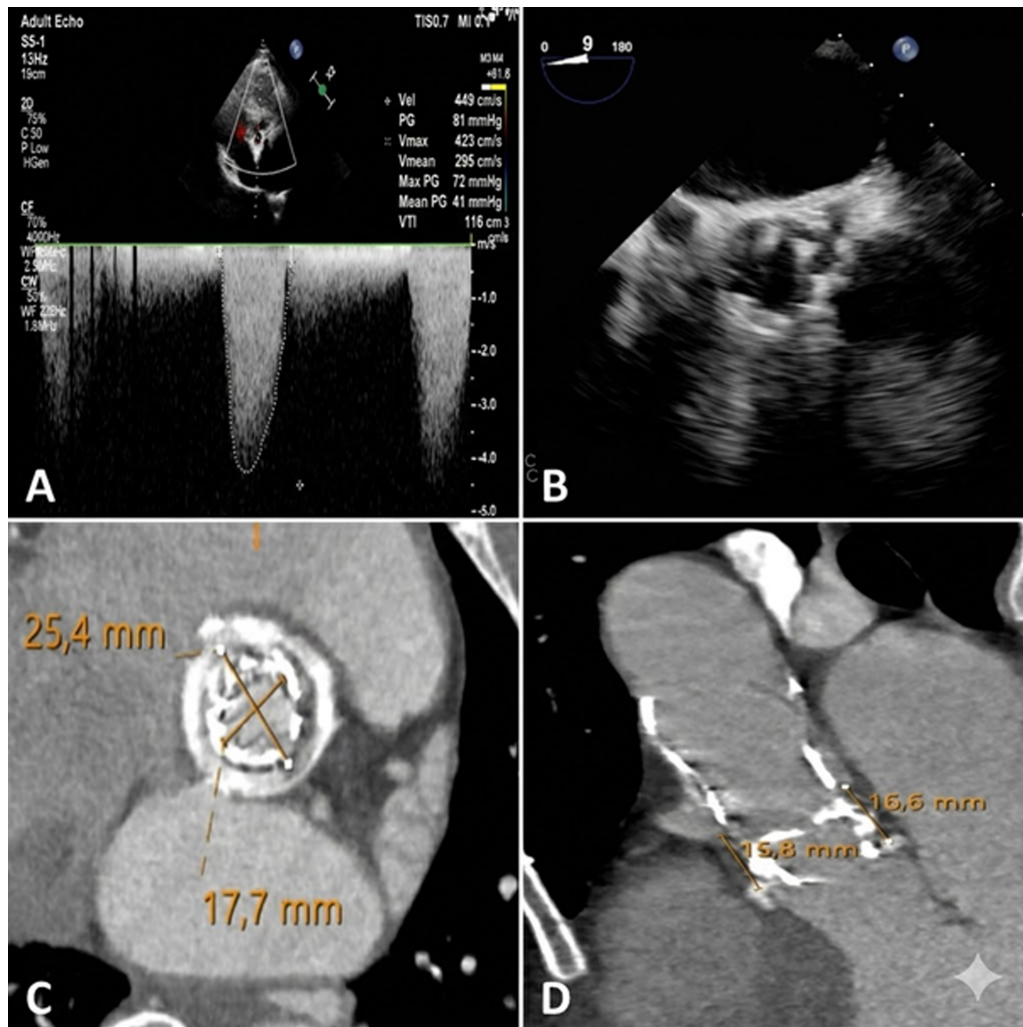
Pre-procedural imaging. (A) TTE CW Doppler (gradients 81/41 mm Hg, Vmax 449 cm/s). (B) TEE (bioprosthetic SVD). (C) Axial MDCT (luminal dimensions 25.4×17.7 mm). (D) Coronal MDCT (ostial clearance: LCA 15.8 mm, RCA 16.6 mm). CW, continuous-wave; LCA, left coronary artery; MDCT, multidetector computed tomography; RCA, right coronary artery; SVD, structural valve deterioration; TEE, transesophageal echocardiography; TTE, transthoracic echocardiography; Vmax, maximum velocity.
